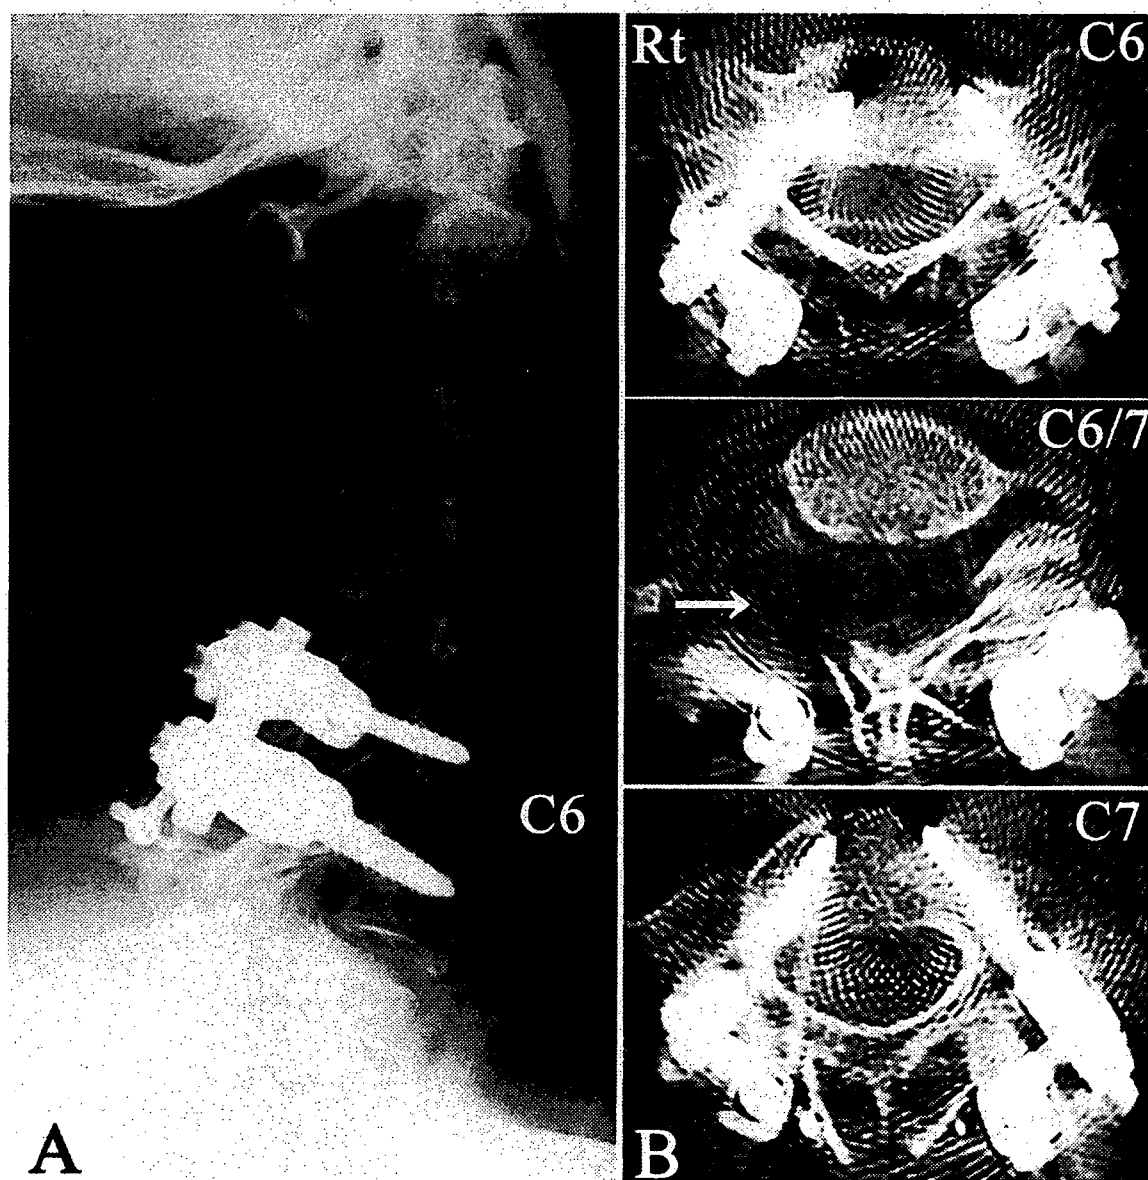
Follow-up imaging studies. A: Plain lateral radiograph obtained 1 year after surgery showing complete reduction of the C6–7 subluxation and spinal fusion after application of the PS/rod system. B: Axial CT scans obtained at the C6 (upper), C6–7 (center), and C-7 (lower) levels taken 3 weeks after surgery demonstrating proper insertion and positioning of the PSs and extensive unroofing of the right C-7 nerve root (arrow).
